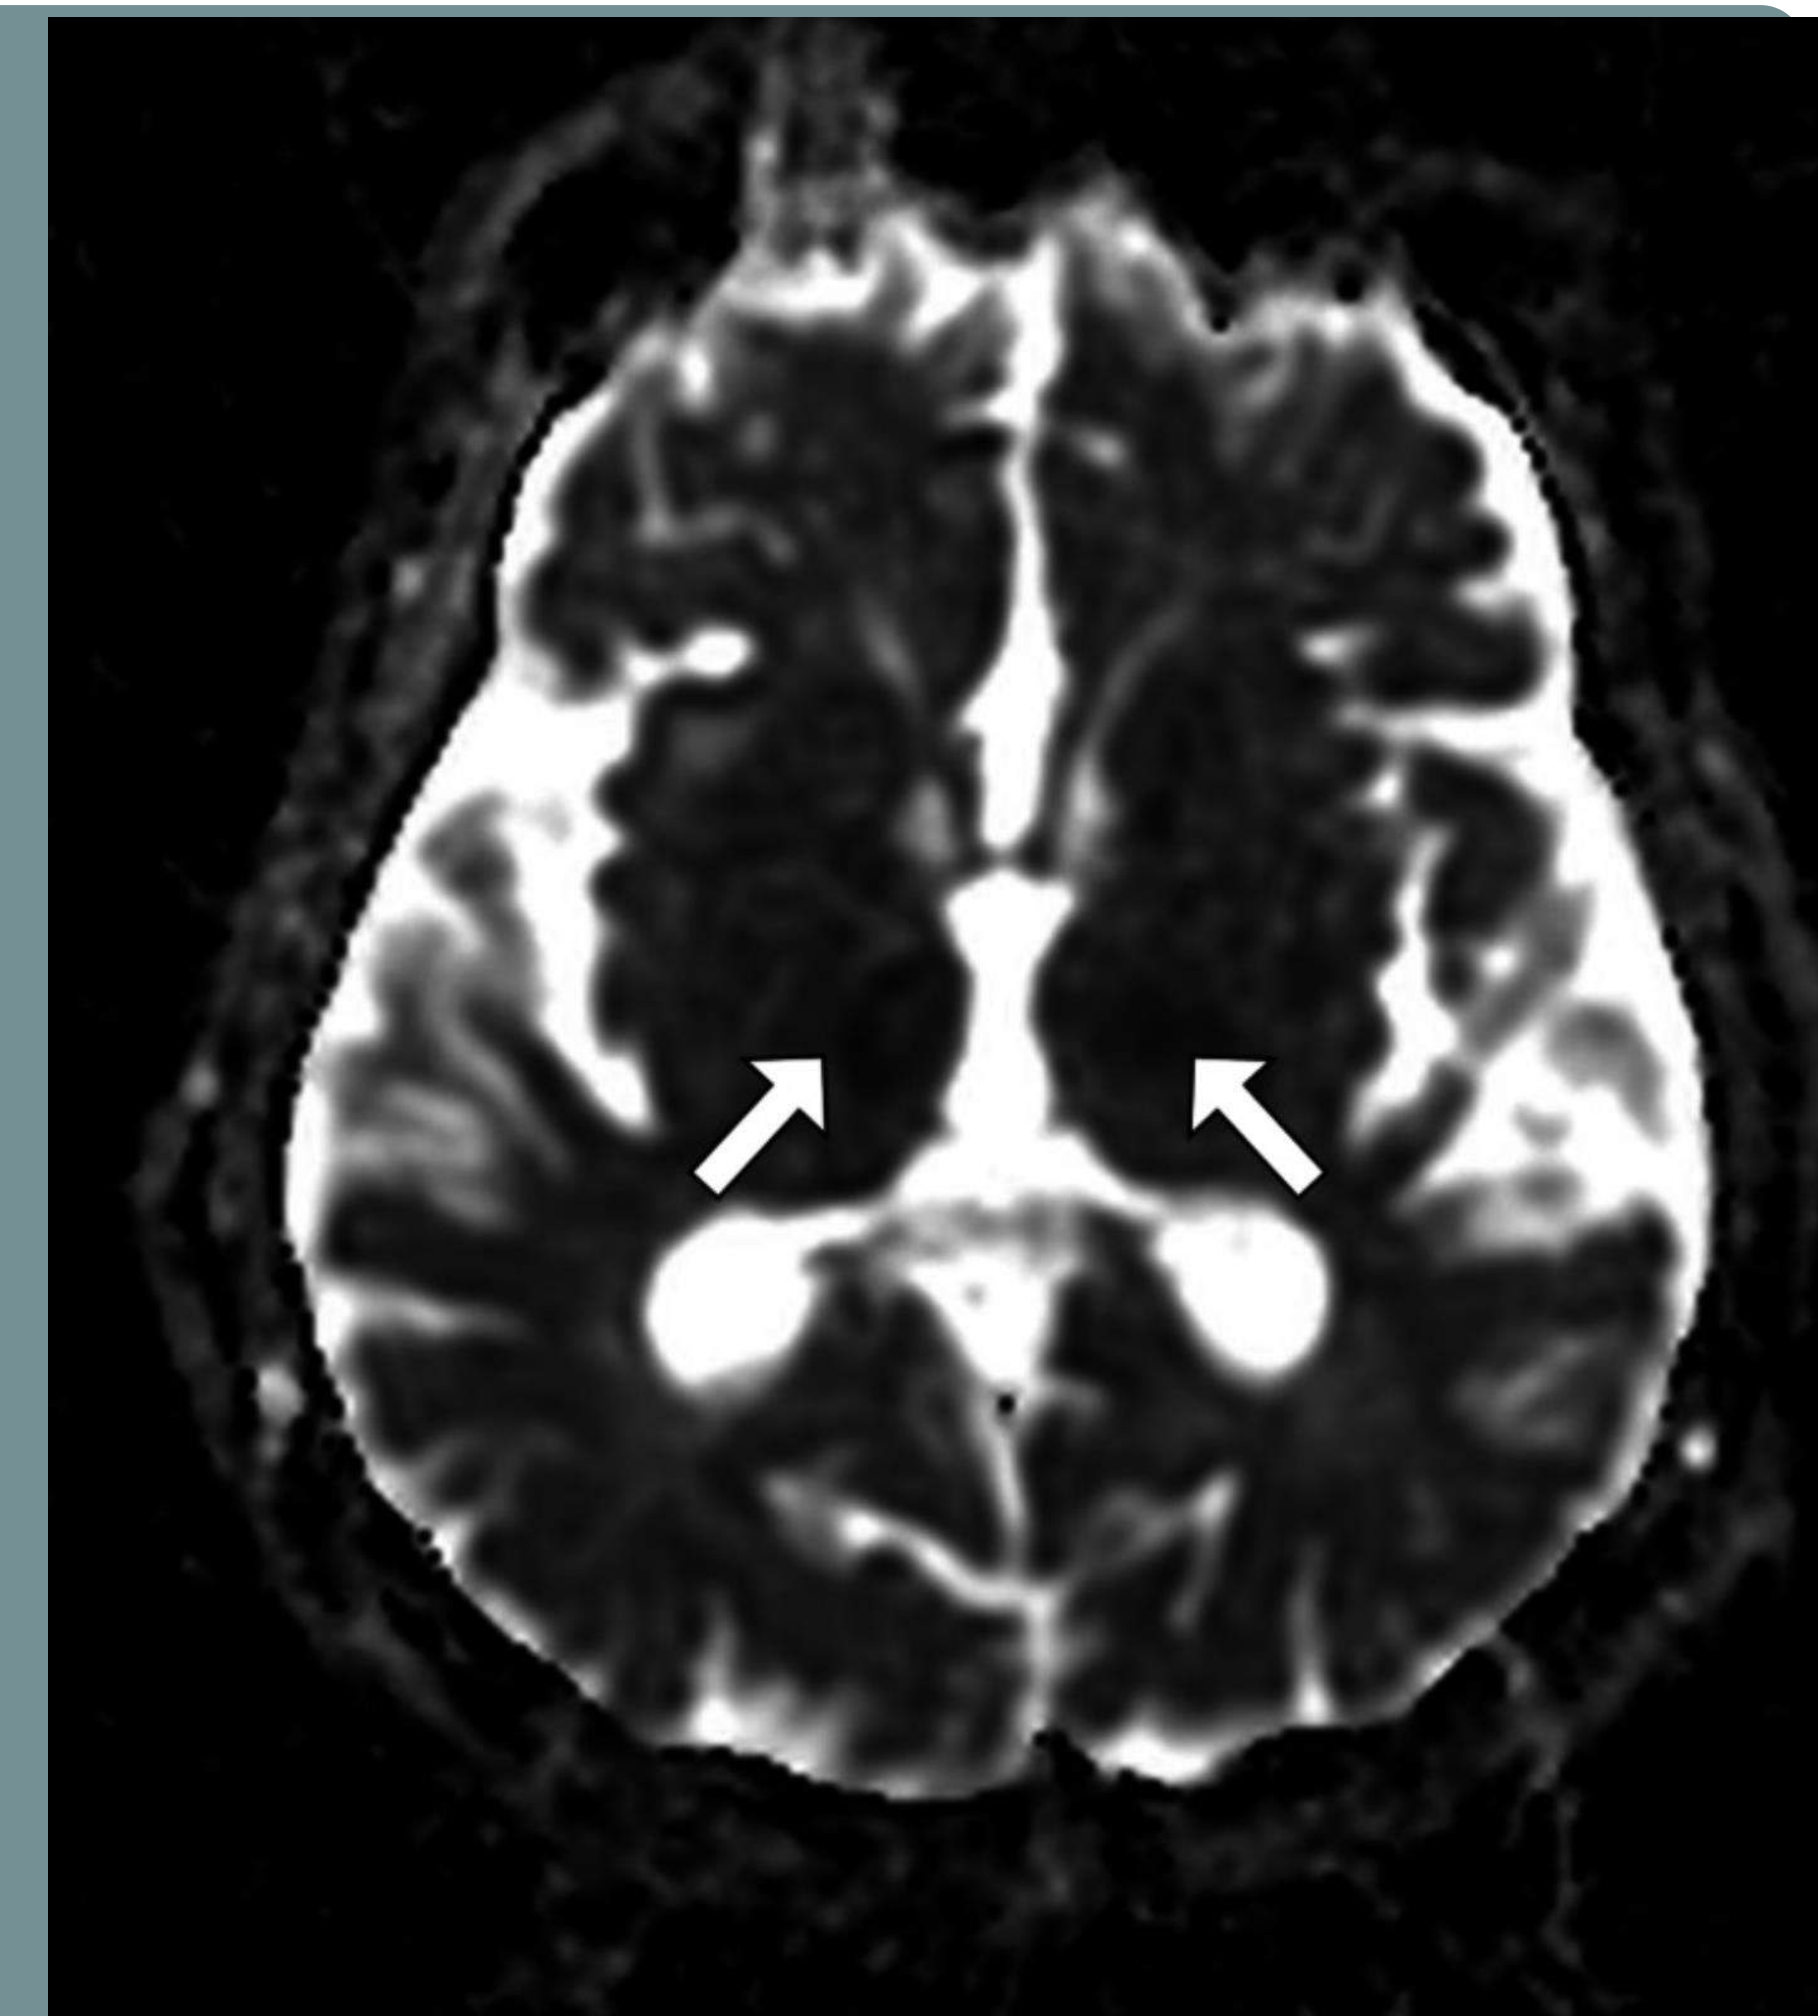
MRI ADC map image of the brain shows decreased diffusion in both thalami
